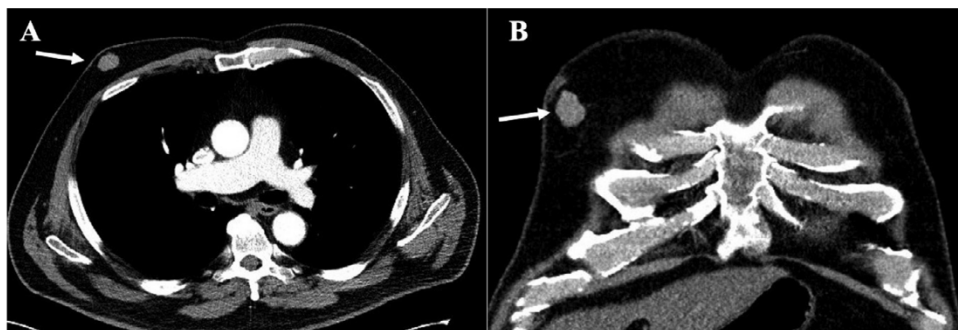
CT of the chest with contrast. Axial (A) and coronal (B) images demonstrate a right retroareolar breast mass (arrow) measuring approximately 2.3 cm size.
